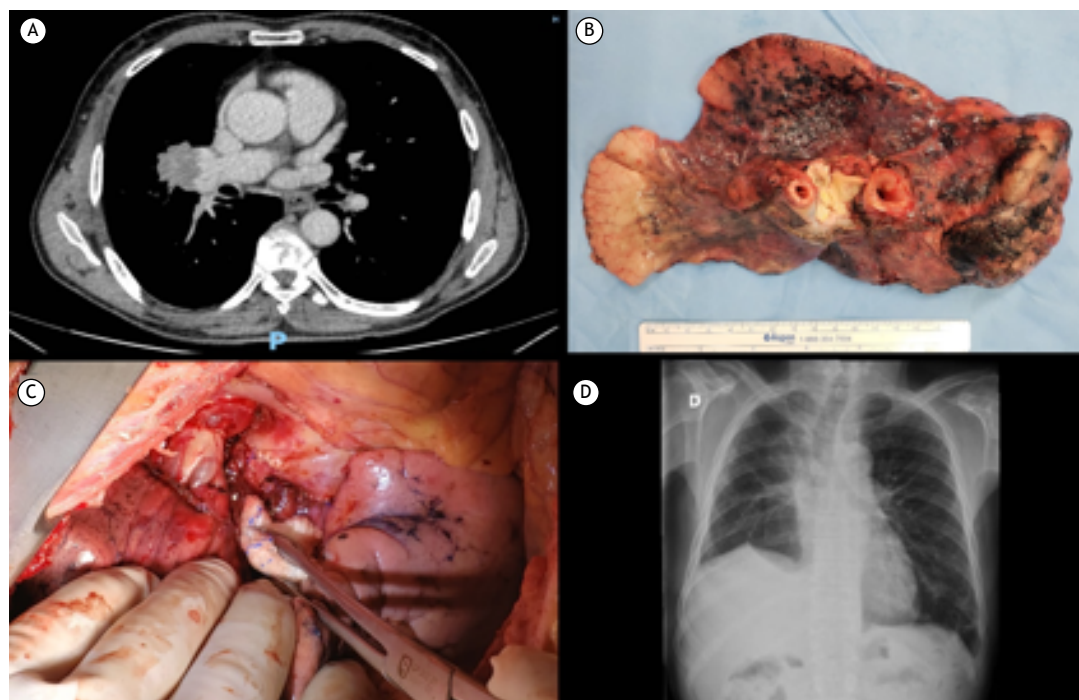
A: Preoperative axial tomographic section; B: Surgical resection showing intimate relationship of the tumor with the bronchovascular structures; C: Perihilar anastomosis after graft implantation; D: Late postoperative chest radiography.
